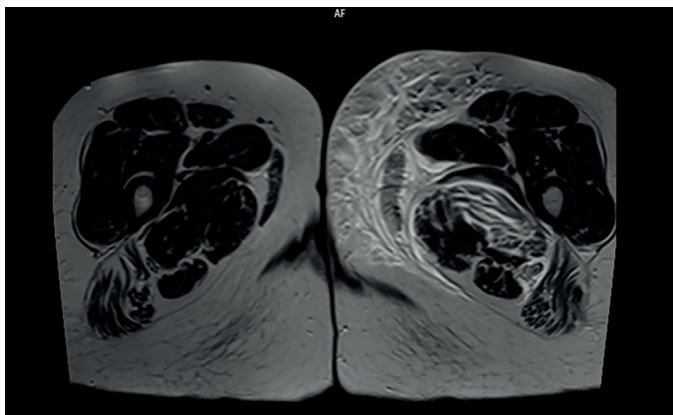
Magnetic resonance imaging of the left medial thigh revealing a well-defined hematoma
